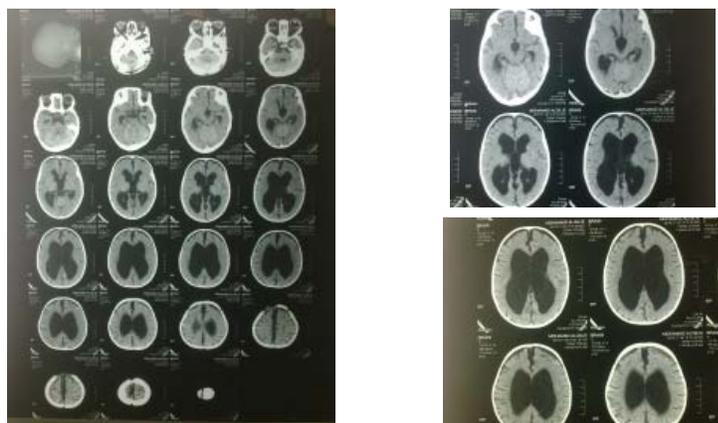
The CT brain showing the dilated ventricles together with ballooning of the third ventricle
